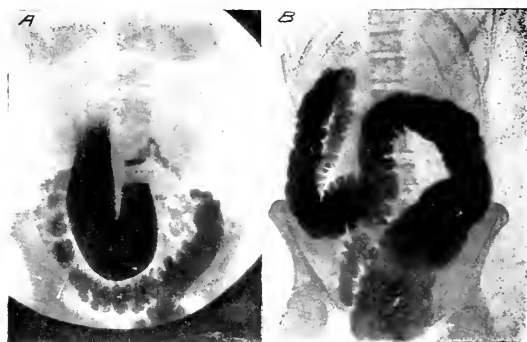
A*. Immediate and twelve hour roentgenogram showing moderate motility of cecum and extreme motility of hepatic angle of colon in an asthenic patient. (Plate taken in erect position.) *B*. Enema plate of same patient showing extreme motility of hepatic angle. (Plate taken in prone position.)
